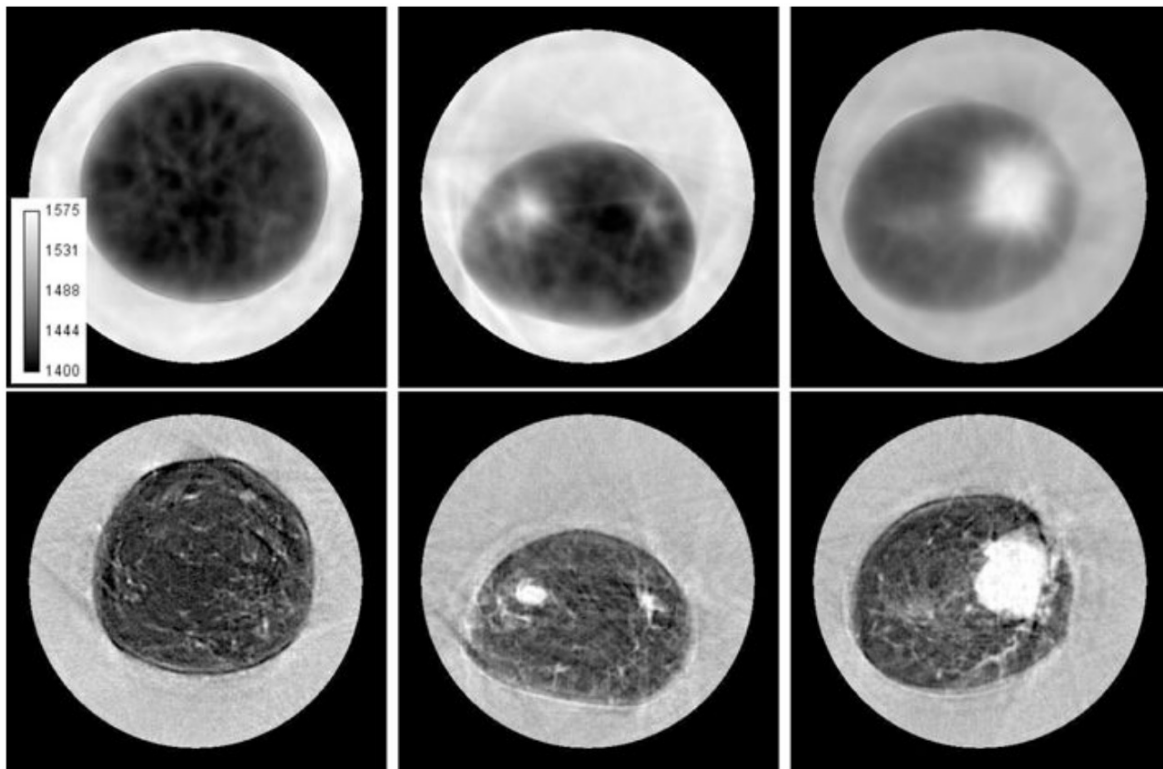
Comparison of speed of sound reconstructions using traveltime tomography (upper row) and FWI (lower row). Data were obtained using the SoftVue ultrasound system (Duric et al., 2014). From left to right breasts with a fine pattern of fibroglandular tissue, a tumor with a diameter of 1 cm and a tumor with a diameter of 4 cm are shown. Gray scale values correspond to speed of sound values from 1400 m/s to 1575 m/s as specified in the colorbar in the upper left corner (Sandhu, 2015).
